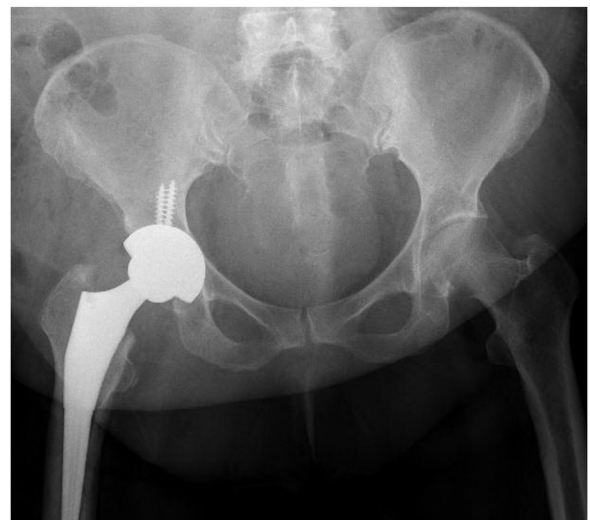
Case 2; post-operative anteroposterior and lateral hip radiographs following a total hip arthroplasty.
